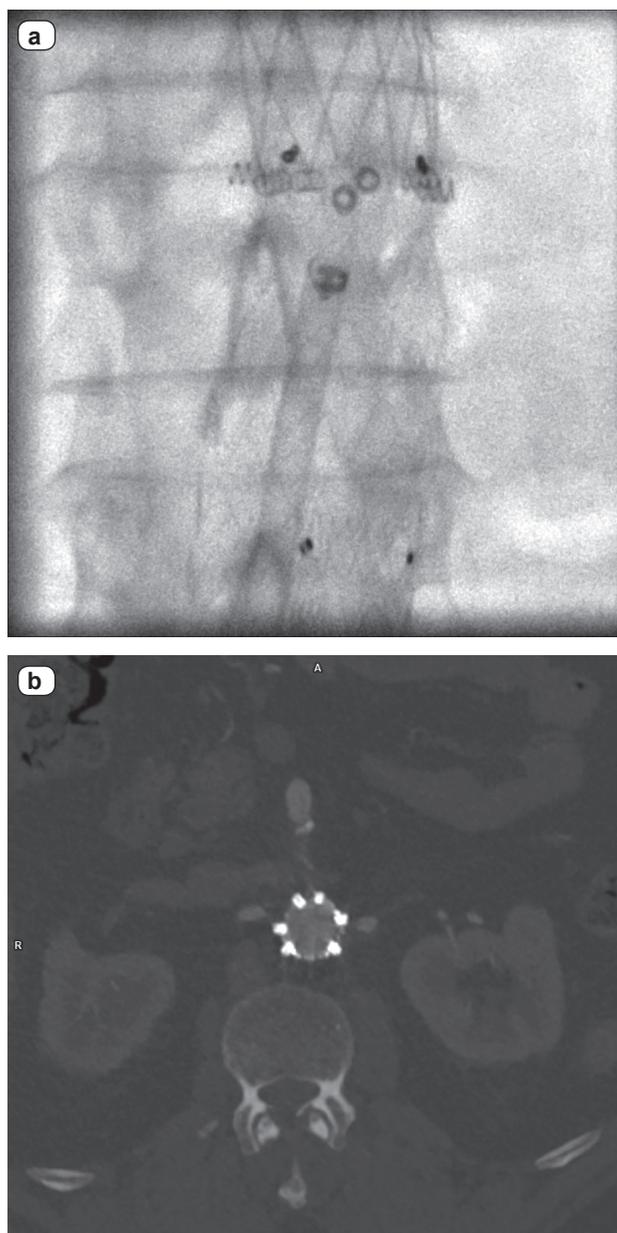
DSA (a) and CTA (b) images demonstrate distribution of EndoAnchors around the circumference of the endograft.
